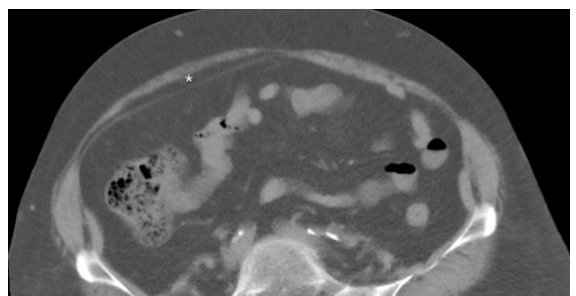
Axial unenhanced CT scan performed 3 weeks before, retrospectively, shows the arcuate line hernia with minimal bulging of intraperitoneal fat (*).
